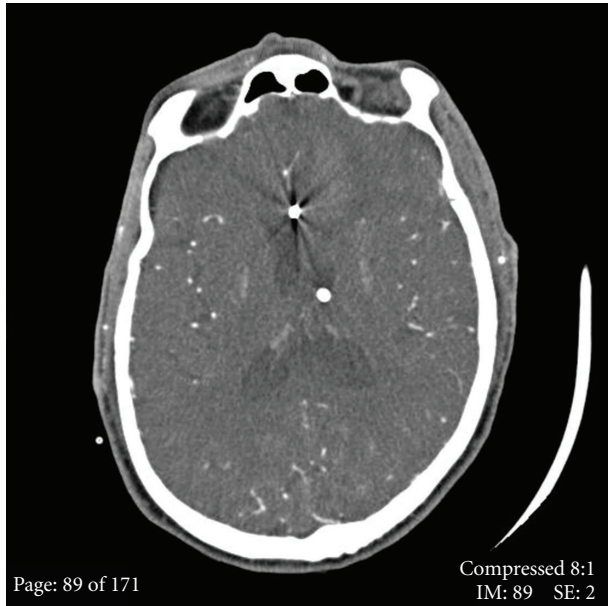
One week postoperative CT imaging demonstrating a metallic clip in the ACA, and a ventriculostomy in the lateral ventricle.
